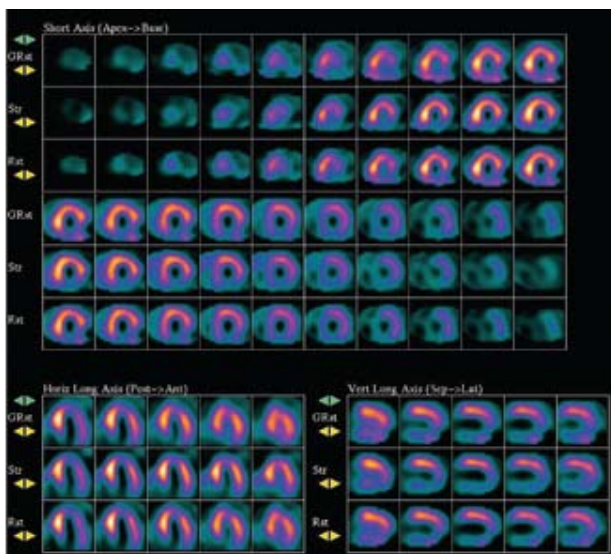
Myocardial perfusion single-photon emission computed tomography demonstrates inferior wall infarction.
